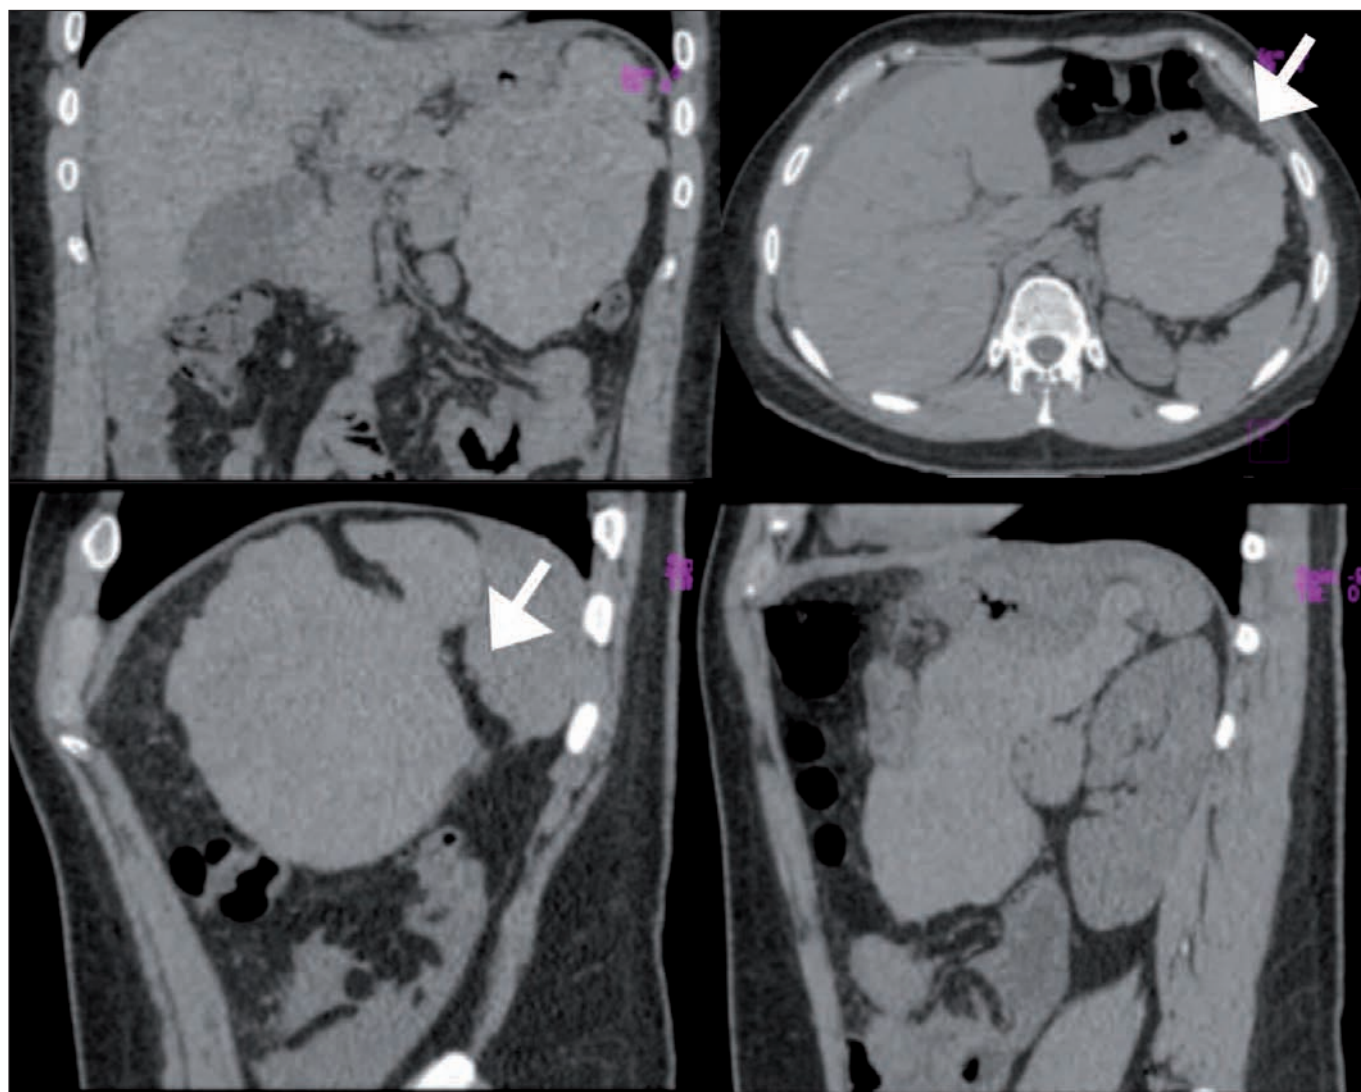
Abdominal computed tomography: hematoma in the lesser sac (white arrow).
